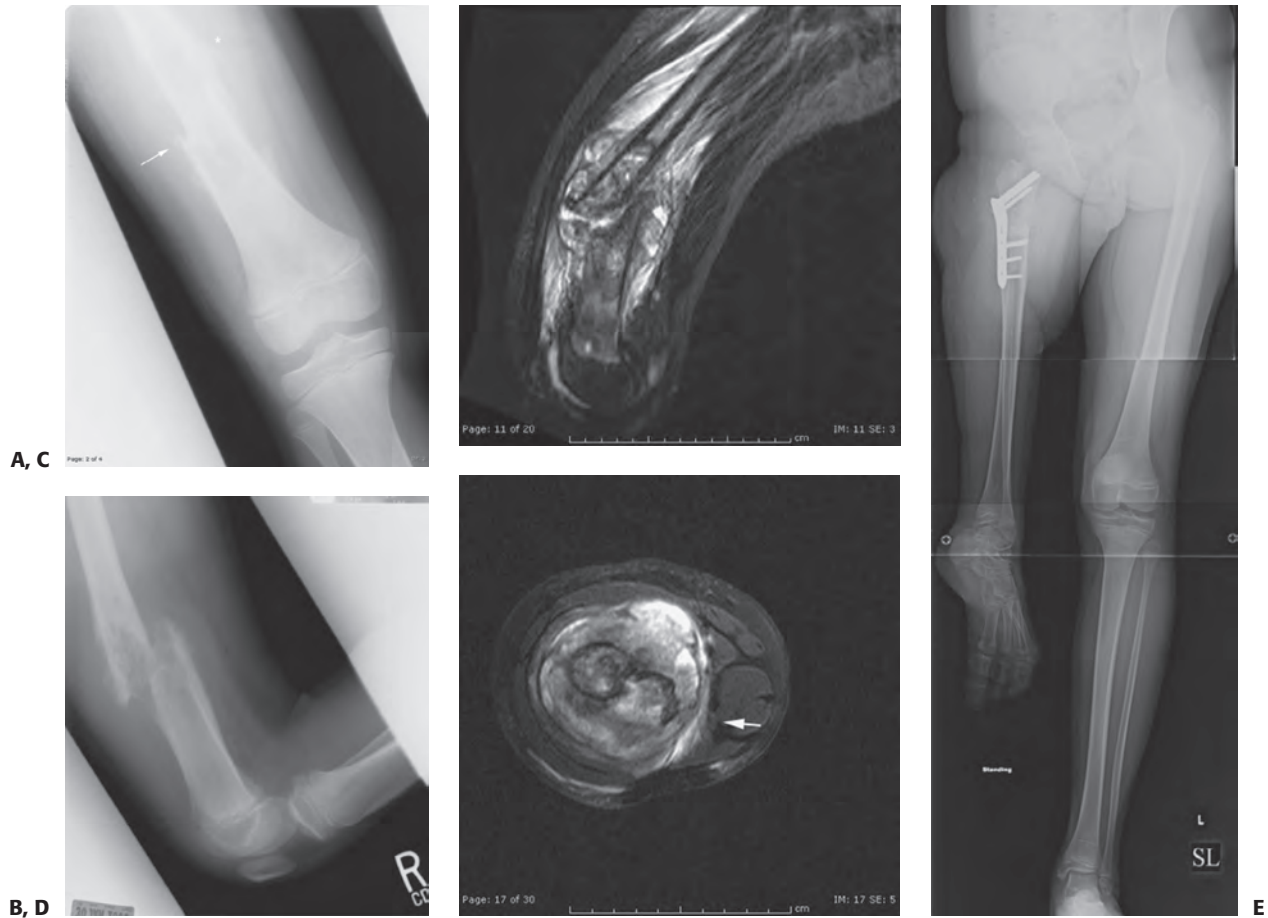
An 8-year-old girl sustained a pathologic fracture of the femur after falling off her bicycle. She denied symptoms previous to this injury. The radiographs (A, B) showed a grossly displaced fracture through a poorly defined, mixed lesion in the midshaft of the femur (*arrow*); there is disorganized periosteal reaction with sunburst sign. T2-weighted coronal (C), and axial (D) MRI showed extensive soft tissue mass; the neurovascular bundle (*arrow*) does not seem to be involved by the tumor mass. The patient underwent biopsy that confirmed osteogenic sarcoma and fracture stabilization with an external fixator at a referring institute. Note that the external fixator pins were inappropriately placed too far from the tumor and fracture site (E) postoperative appearance following Van Ness rotationplasty. The patient is continuously free of disease, 5 years after surgery.
